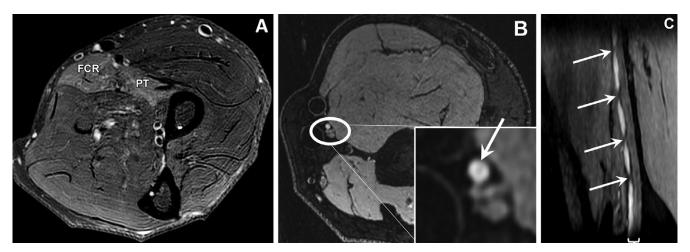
Patient 1: A 49-year-old man with Parsonage-Turner syndrome that developed 13 hours following the first dose of the Pfizer-BioNTech (BNT162b2) COVID-19 vaccine. (A) Axial T2-weighted fast-spin echo fat-suppressed image 8 weeks after symptom onset demonstrates denervation edema pattern of the pronator teres (PT) and flexor carpi radialis (FCR) muscles. (B) Axial T2-weighted gradient-echo image demonstrates abnormal signal hyperintensity of the PT/FCR, anteromedially positioned, fascicular bundle (arrow, magnified inset) of the median nerve (oval) within the distal arm. (C) Oblique sagittal curved multiplanar reformatted T2-weighted gradient-echo image demonstrates multiple severe intrinsic constrictions (arrows) of the PT/FCR bundle of the median nerve (bracket).
